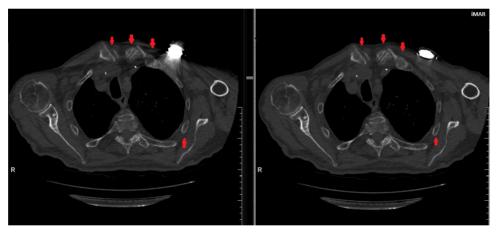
Thoracic CT scan. Left: unreconstructed image. There are many artifacts on the rib cage caused by a metallic device. Right: reconstructed MAR image. The application of the MAR algorithm showed a reduction in metal artifacts caused by the metallic device.
